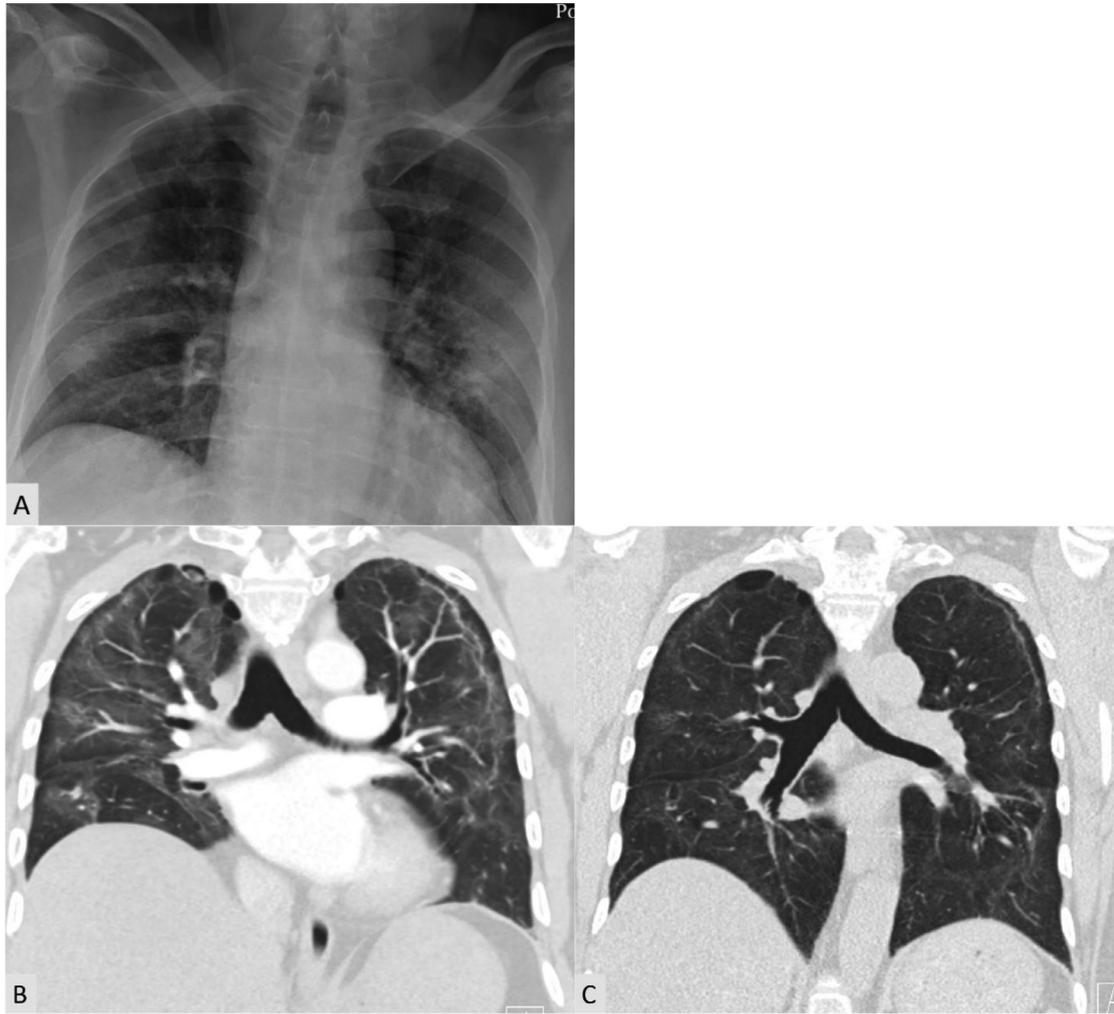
(A) Initial chest radiograph demonstrates mild to moderate acute COVID-19; (B) Two months later, coronal reformatted CT demonstrates moderate amount of bilateral ground-glass opacity with reticular opacities paralleling the pleura, indicating an element of organization; (C) Coronal reformatted CT at nine months demonstrates improvement in ground-glass opacity with persistent more reticular opacification, indicating organization with residual fibrosis.
